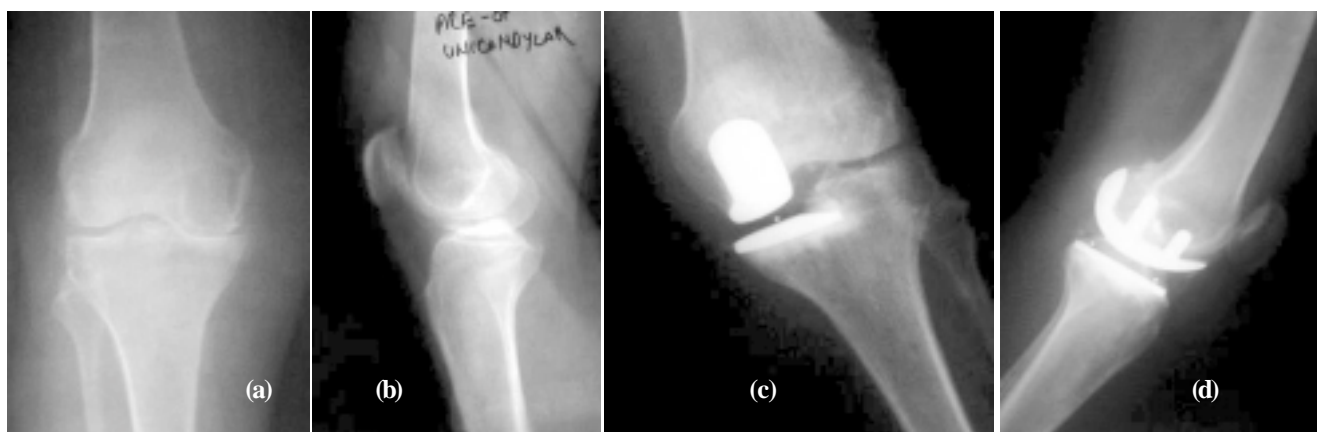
(a,b) X-rays AP and lateral view showing medial compartment osteoarthritis, (c, d) Post-operative X-rays, (e) Clinical photographs showing flexion at knee-joint.
